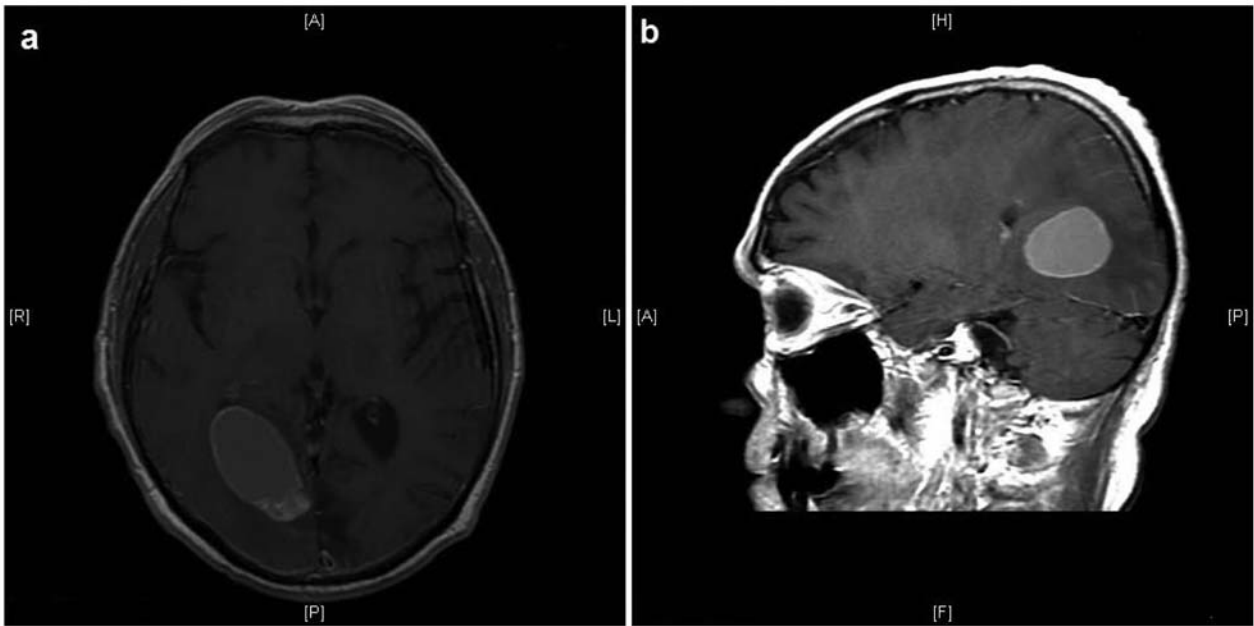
a: Axial preoperative MRI imaging with contrast. b: Sagittal preoperative MRI imaging with contrast.
